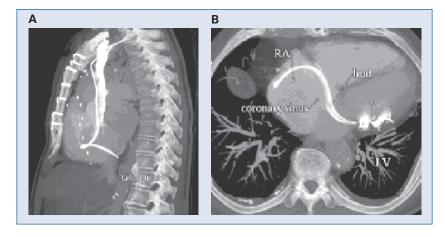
A. Computed tomography of the chest demonstrated a single ventricular lead, posteriorly directed towards the left ventricle; B. The tip of the lead traveled from the right atrium (RA) through the coronary sinus and resided within the infero-posterior coronary vein over the left ventricle (LV).
